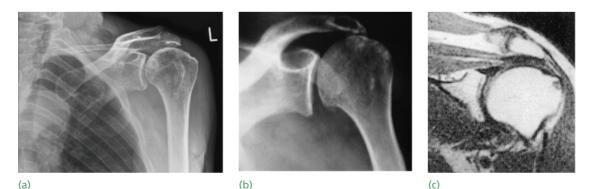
Supraspinatus tendinitis – X-rays (a) X-ray of the shoulder showing a typical thin band of sclerosis at the insertion of supraspinatus and narrowing of the subacromial space. The rest of the joint looks normal. (b) X-ray at a later stage showing upward displacement of the humeral head due to a large cuff rupture. There is almost complete loss of the subacromial space, and osteoarthritis of the glenohumeral joint. (c) MRI showing thickening of the supraspinatus and erosion at its insertion; the acromioclavicular joint is swollen and clearly abnormal.
